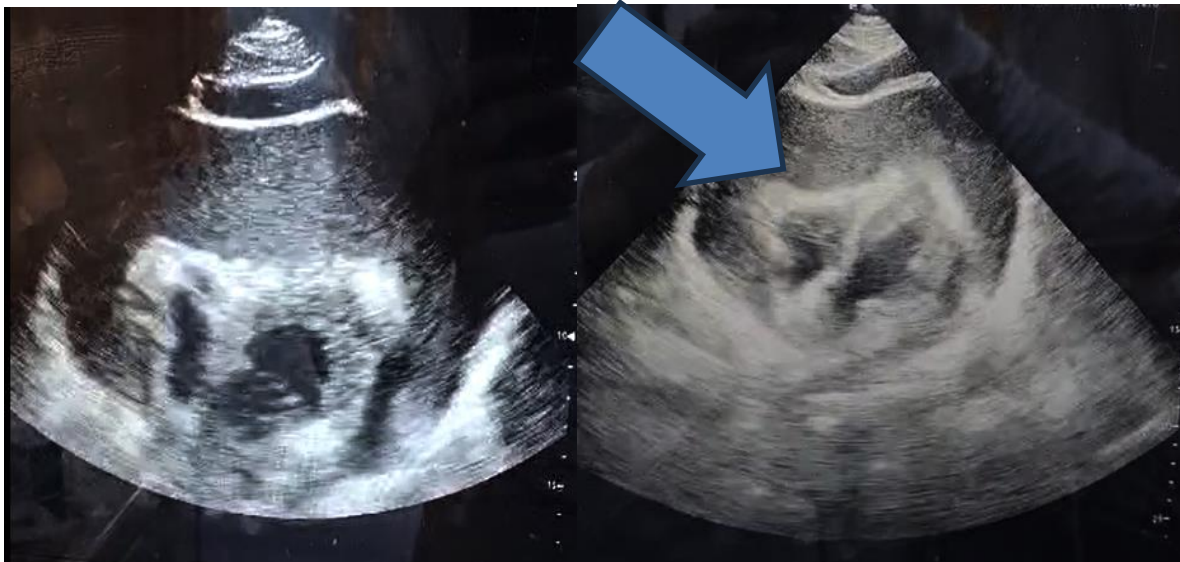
Transthoracic echocardiography showing a large pericardial effusion and a swinging heart. The blue arrow indicates the collapse of the right-sided chambers.
